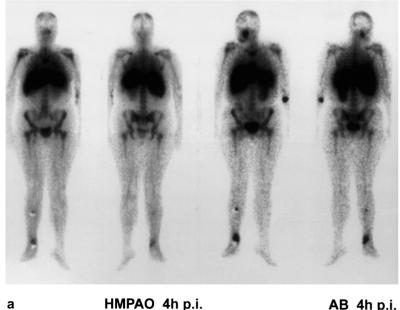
Fifty-six year old woman with post-traumatic osteomyelitis of the upper and lower right tibia. Imaging was performed with both methods 4 h. p.i., and the findings at this site were consistent (a). In addition, the SSEA-1 antibody scan showed focally increased uptake at the right nasal sinus, which was not recognized on the ^{99m}Tc-HMPAO scan. Sinusitis was confirmed by normal radiography (b)
